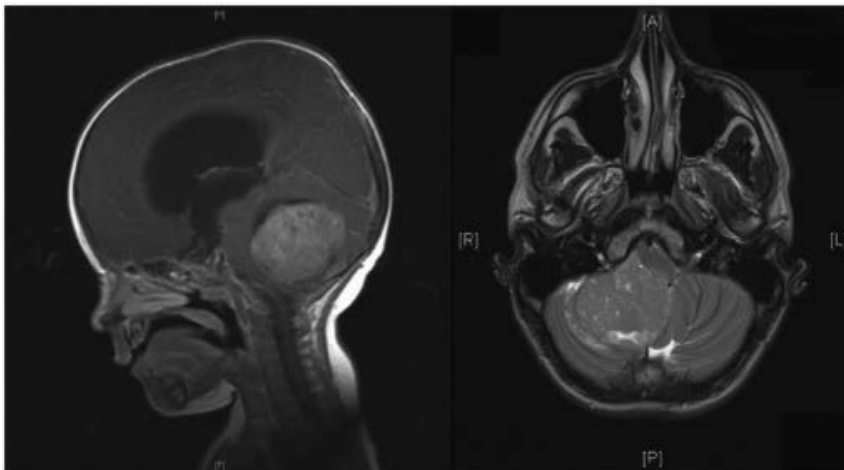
Medulloblastoma is a primitive neuroectodermal tumor commonly arising in the cerebellar vermis. The left image is a sagittal view of an MRI for a pediatric patient. The right image is a horizontal view of an MRI showing tumor growth towards the right cerebellar hemisphere, with displacement of the vermis. Copyright © 2014 from *Pediatric medulloblastoma—update on molecular classification driving targeted therapies* (DeSouza, Jones, Lewis and Kurian, *Front. Oncol.* 2014).
